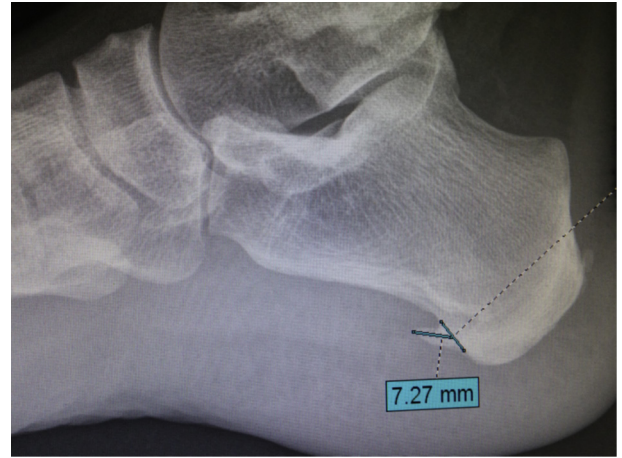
Lateral calcaneal roentgenogram of demonstrates the calcaneal spur and the measurement method of calcaneal spur length. Two lines are demonstrated. One line demarcating the calcaneal border and another line from the calcaneal border to calcaneal tip.
